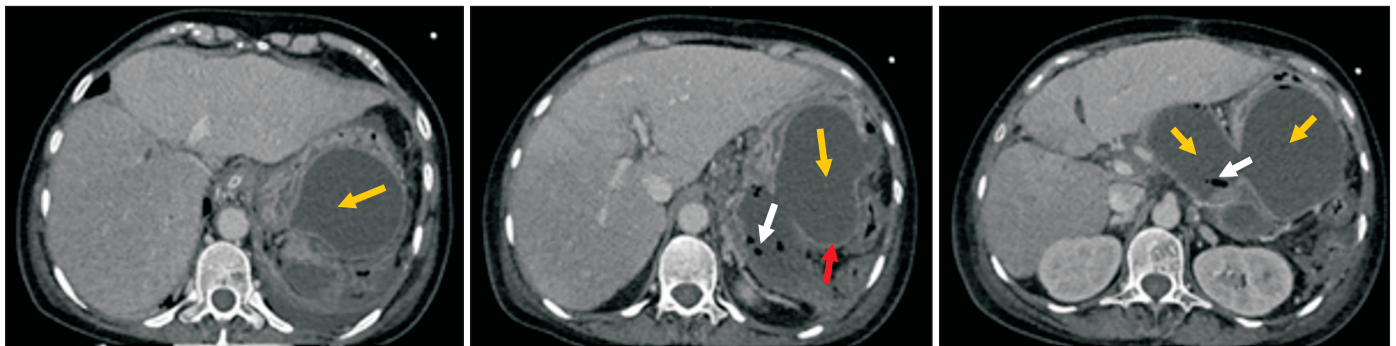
Contrast-enhanced computed tomography of the abdomen reveals extensive inflammatory changes in the pancreas, affecting the body and tail, with necrosis exceeding 50% (Balthazar E). Orange arrows indicate large multiloculated retroperitoneal, peripancreatic, and retrogastric collections, extending to the left anterior pararenal space. Red arrow denotes a thick peripheral capsule with contrast enhancement, and the presence of gas within these areas (white arrows) suggests signs of an infected collection.
